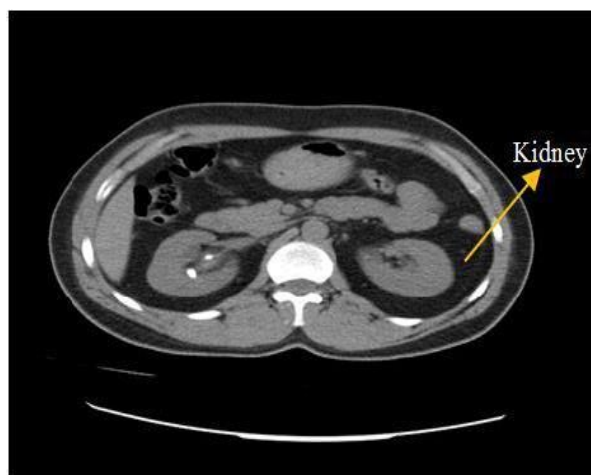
The Sample of a KUB CT scan slice
